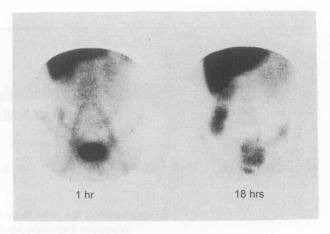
A repeat scintigraphy performed 5 months later, revealed intense accumulation of the radiotracer in the ascending and the sigmoid colon at 18 hours, which was suggestive of progress in his clinical status.
